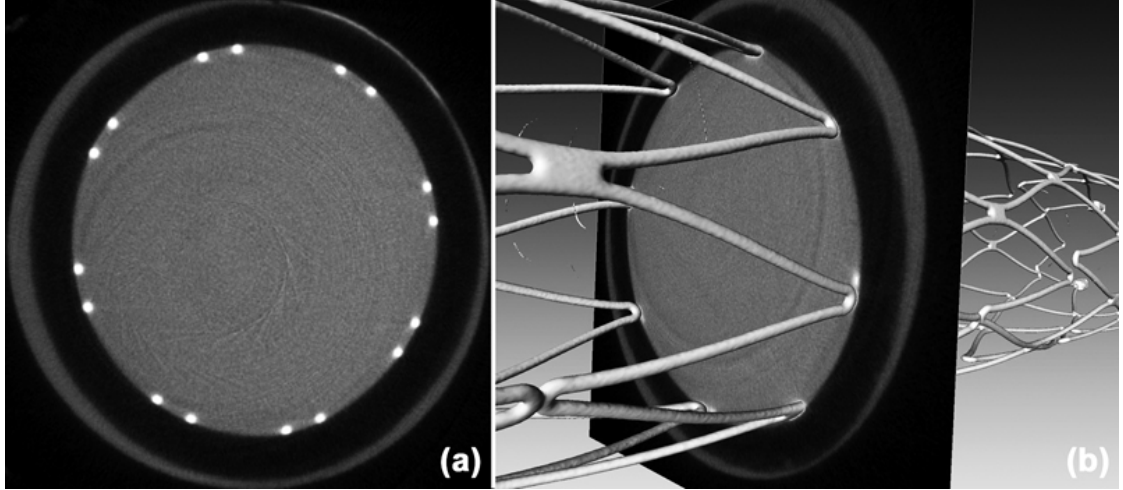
Micro computed tomography slice showing the lumen (gray) and stent struts (white) in (a) and the reconstructed stent surface in (b) based on attenuation values
